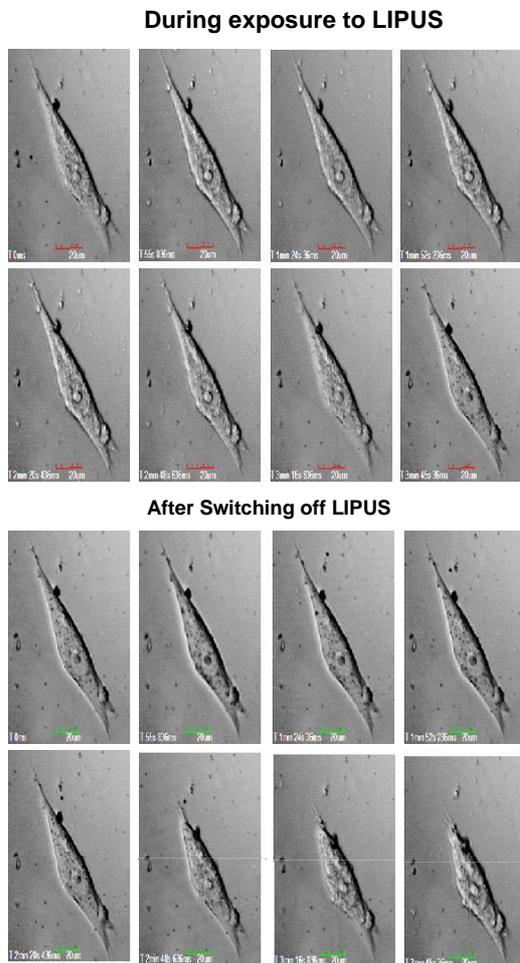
Time series bright field images showing cytomorphological changes of MG 63 cells during 1-MHz ultrasound pulsing with 30mW/cm² spatial peak time averaged ultrasound intensity and burst rate of 1 kHz at an interval of 200µs for 3min 45 sec time duration. Time-lapse cell shrinkage is evident during post exposure ultrasound period while cell expansion during ultrasound exposure is relatively less prominent.
